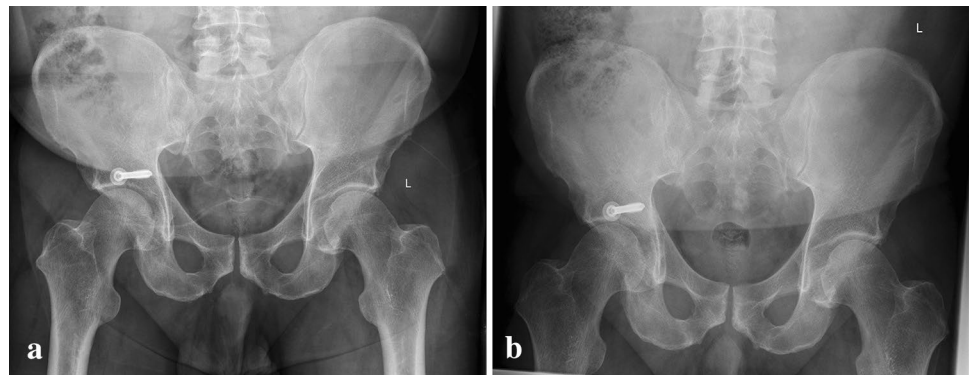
Follow-up a.p. pelvis X-rays a 6 weeks and b 12 weeks after minimally invasive navigated surgery of the right acetabulum
